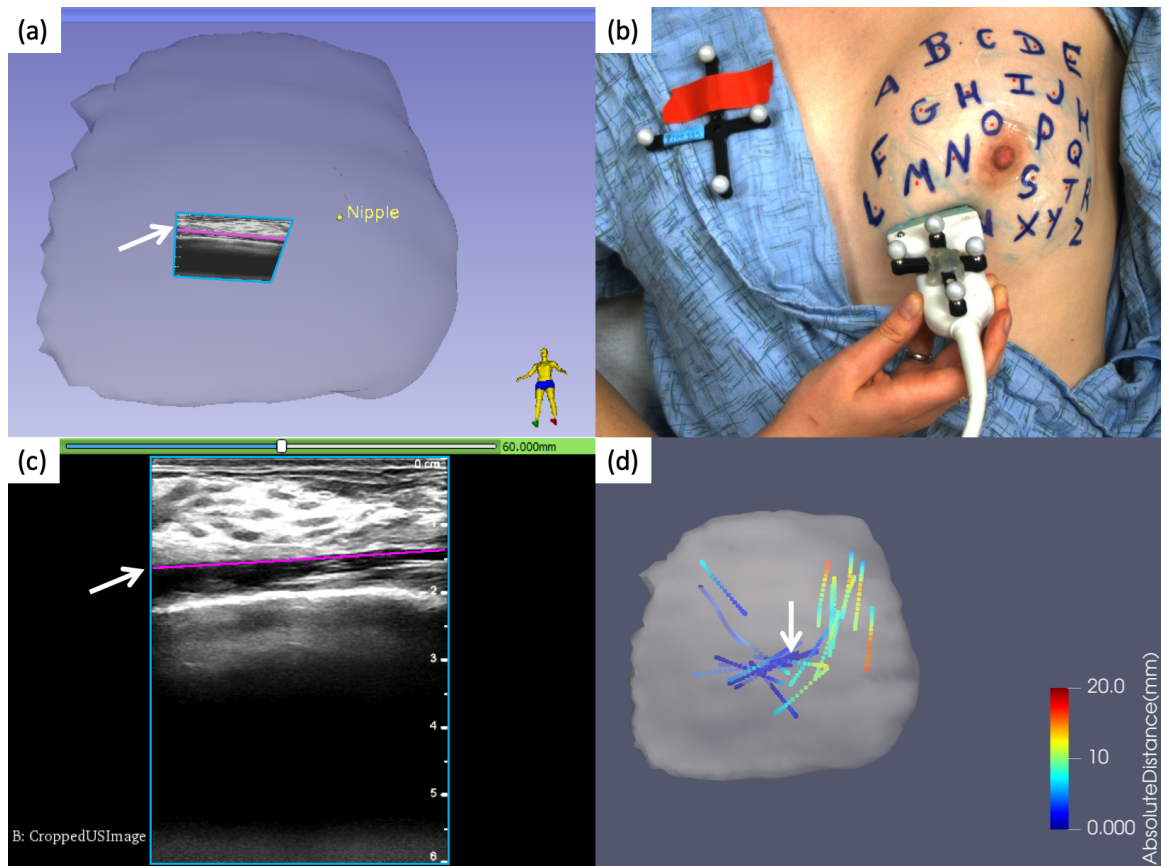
Ultrasound data in an image guidance system, with a white arrow indicating this chest wall segmentation: (a) breast model as segmented from the MR image with tracked ultrasound plane in blue, and the chest wall segmented in magenta; (b) ultrasound image acquisition in the mock OR; (c) ultrasound image outlined in blue with the segmented chest wall surface in magenta; (d) acquired chest wall contour data on the breast model where color indicates the closest point residual with its MR counterpart after rigid registration.
